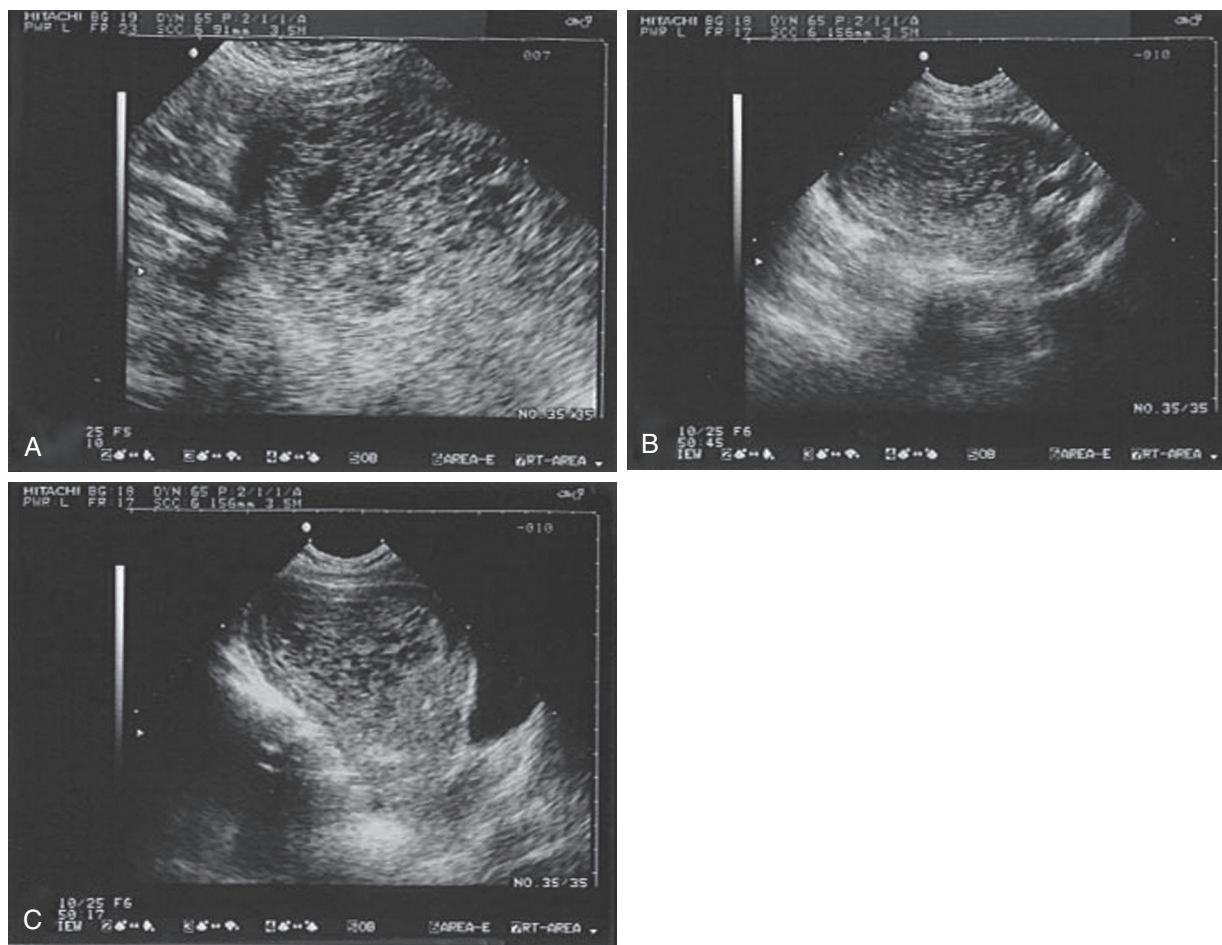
Ultrasonogram showing molar pregnancy. (Courtesy Dr. Mary Ann Edens.)
